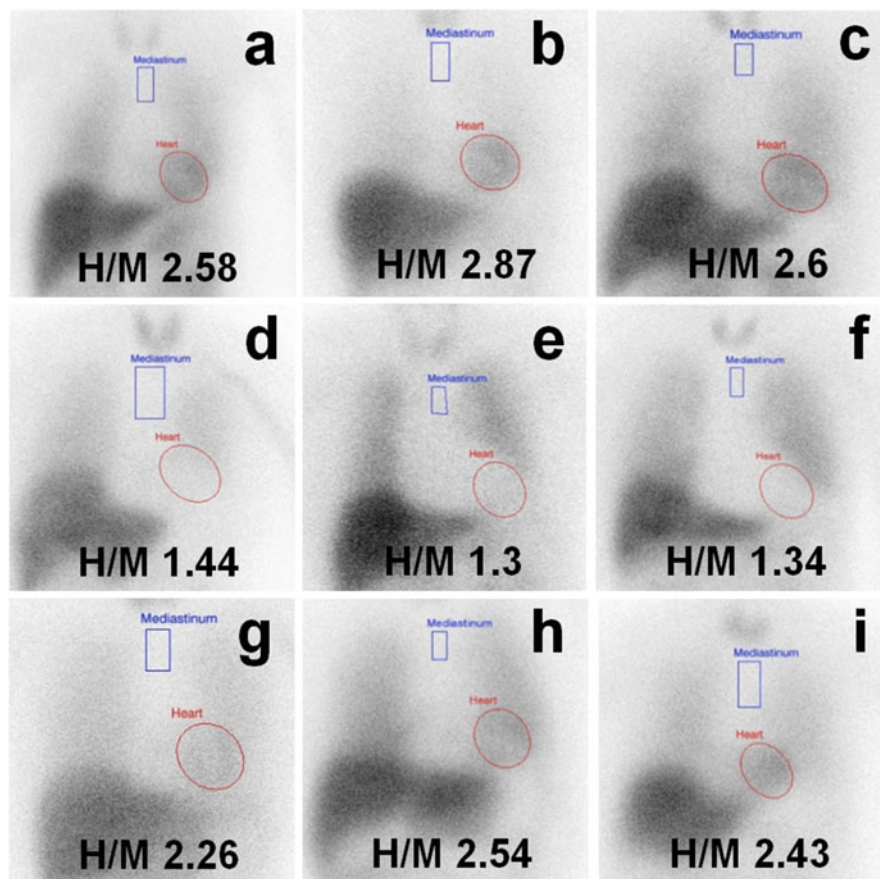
^{123}I -MIBG cardiac scintigraphy in representative cases of Parkinson's disease and related disorders. Cardiac MIBG uptake is lower than normal control in patients with Lewy body diseases such as PD, DLB, and PAF, but not in patients with other related disorders. (a) control, (b) vascular parkinsonism, (c) essential tremor, (d) Parkinson's disease, (e) dementia with Lewy bodies, (f) pure autonomic failure, (g) multiple system atrophy-parkinsonism type, (h) progressive supra nuclear palsy, (i) corticobasal degeneration
